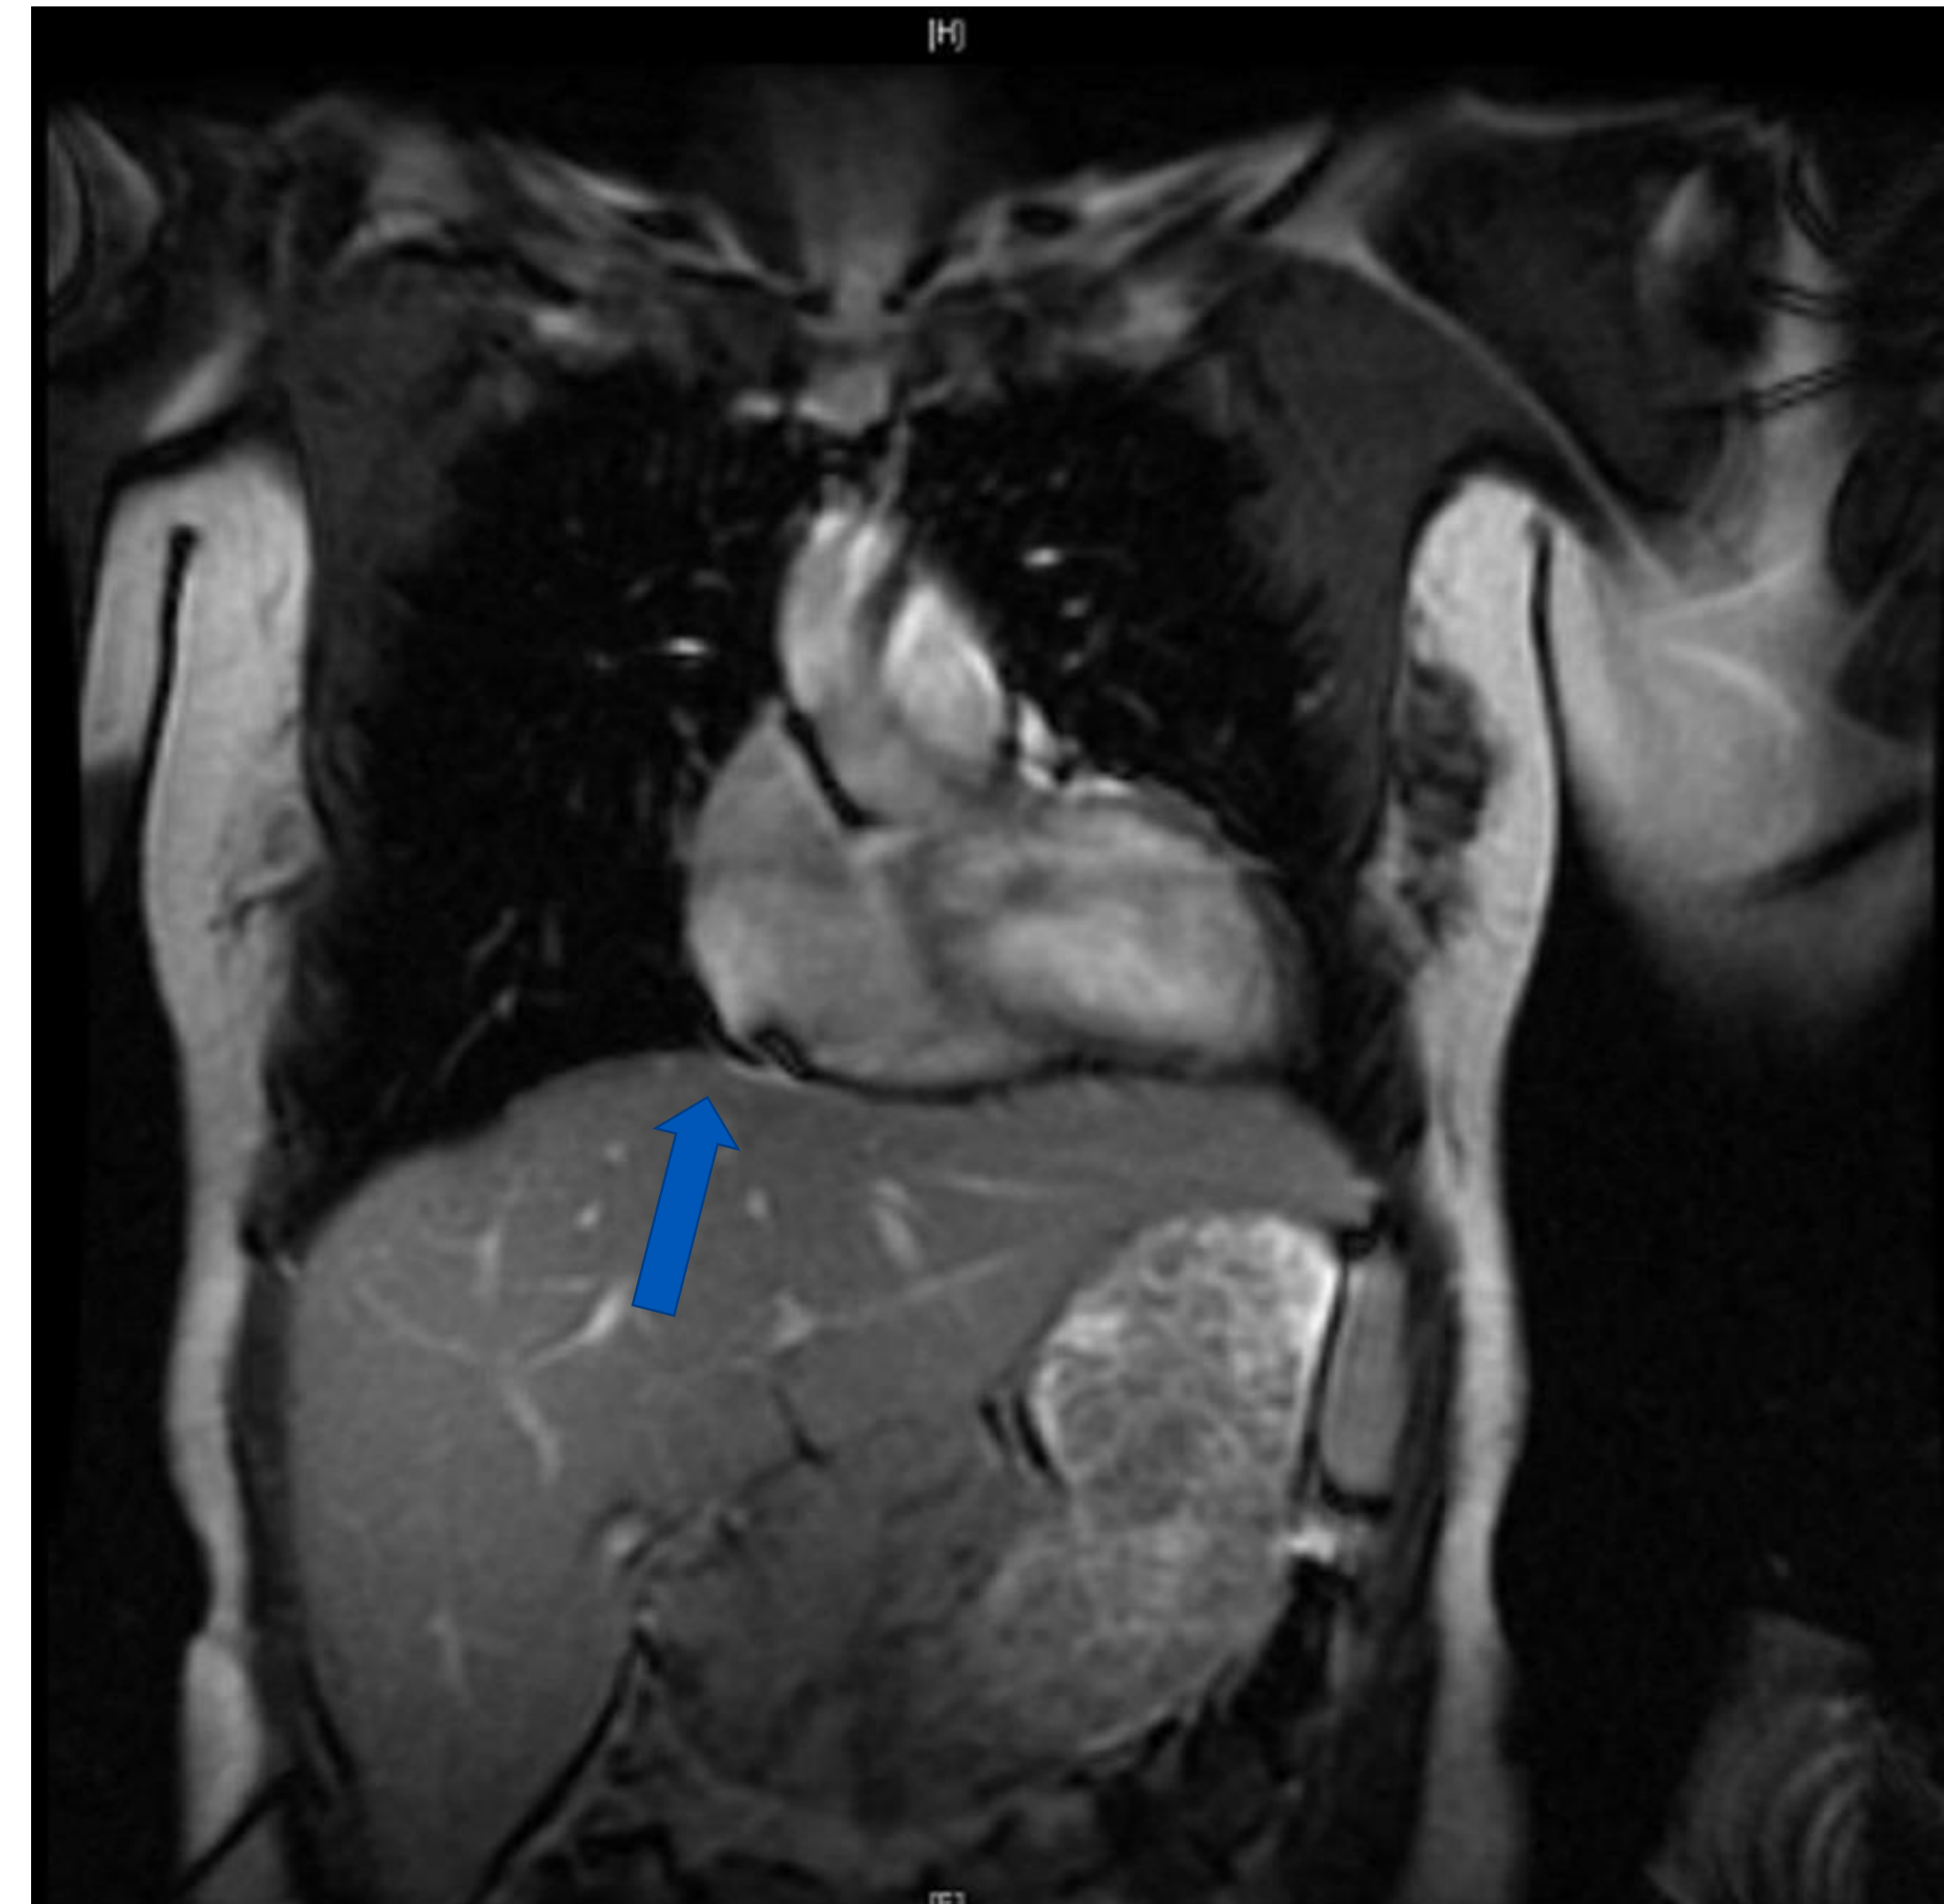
Cardiac MRI showing indentation of mid-apical RV wall (blue arrow)
